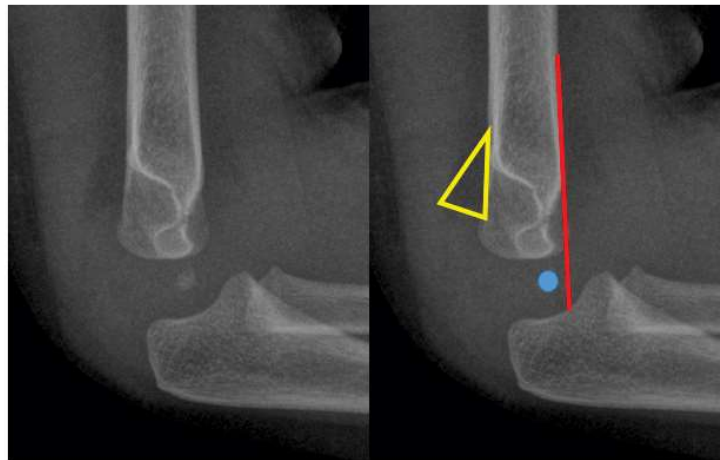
Lateral radiograph of a Type 2 supracondylar humerus fracture with a sail sign (outlined in yellow on the right) indicating an elbow effusion. The anterior humeral line (in red on the right) does not intersect with the capitellum (in blue).
